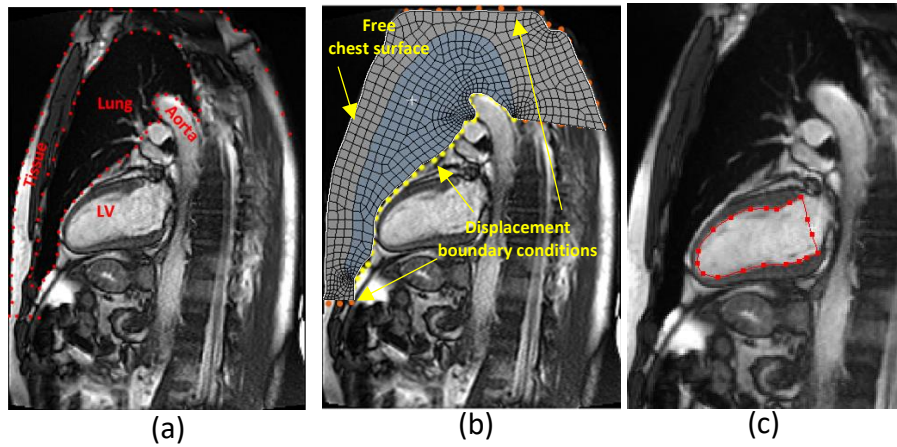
(a) MRI image of the 2-chamber view of the heart with surrounding lung and tissue regions (b) Computational mesh with boundary conditions. (Points specified in yellow color had larger movements relative to the points specified in orange color since they capture the movements due to the blood pumping of left ventricle and aortic blood flow accelerations. Although the points specified in orange color had smaller movements, they were tracked to provide more realistic boundary conditions to the computational model. The boundary on the chest tissue surface allowed to move freely) (c) Blood pool area in the left ventricle.
